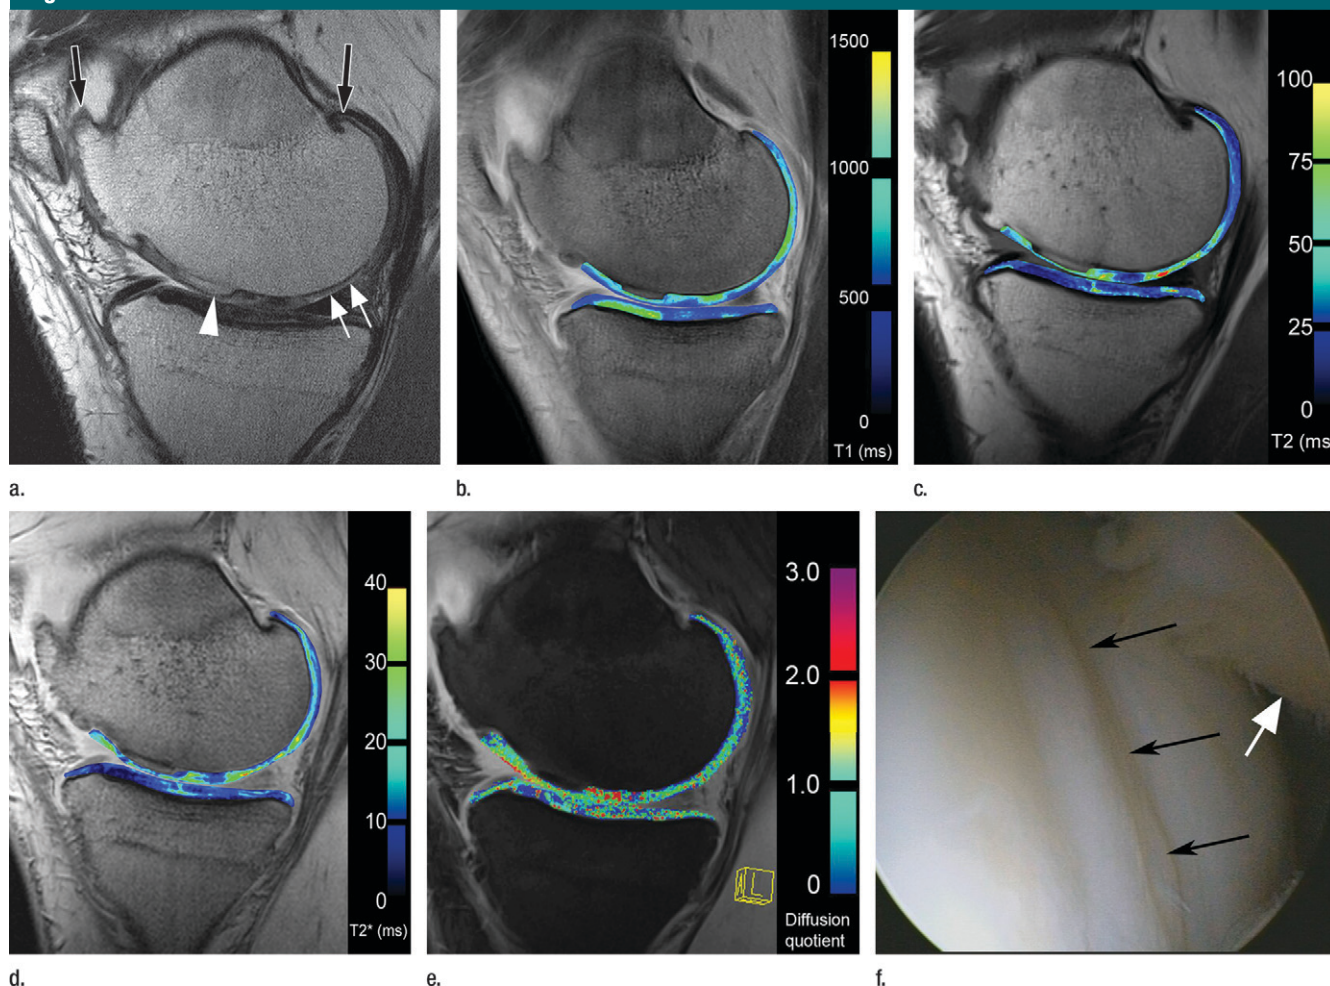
Compositional MR imaging. (a) Sagittal proton density-weighted high-spatial-resolution 3-T MR image (3200/35) of medial compartment of a knee with tibiofemoral OA shows peripheral (black arrows) and central (arrowhead) osteophytes. Focal cartilage thinning is shown in the medial femoral condyle adjacent to the posterior horn of the medial meniscus (white arrows) and in posterior part of the tibial plateau. (b) Delayed gadolinium-enhanced MR imaging of cartilage (dGEMRIC) T1 map (490/13) corresponding to a shows multiple areas with low T1 values, corresponding to low GAG content in superficial layers of femoral cartilage and in posterior part of tibial cartilage (dark blue). (c) Sagittal T2 map (2700/10–70; flip angle, 180°) corresponding to a reveals several areas of increased T2 values in femoral medial condyle and largely corresponding to b. Dark blue = low T2 values, light blue and yellow = higher T2 values. In contrast, only minimal abnormalities in T2 values are seen in tibial cartilage. (d) Sagittal T2* map (177/5.7–26.4; flip angle, 35°) corresponding to a shows comparable abnormalities as those in c. (e) Corresponding sagittal diffusion-weighted MR image (16.3/5.9; flip angle, 30°) shows minor restrictions in diffusion in central region of femoral condyle cartilage and in central and posterior portions of tibial cartilage layer (red). (f) Corresponding arthroscopic image verifies femoral cartilage damage (black arrows). White arrow = posterior horn of medial meniscus. (Fig 11f courtesy of Department of Orthopedics, University of Vienna, Austria.)
